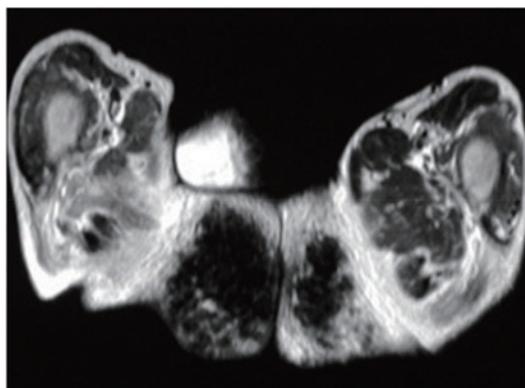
Axial MR images at the level of the buttocks.
